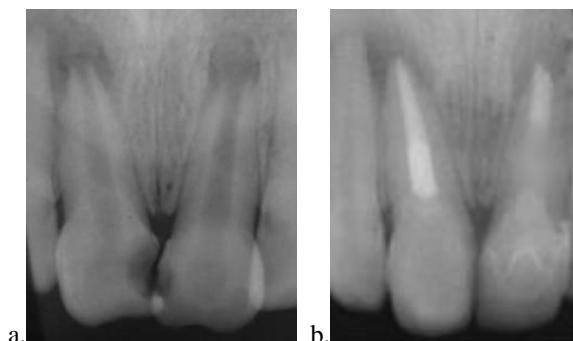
a) Radiographic of tooth 11 and 21 before treatment, showed open apex and apical radiolucency, b) Radiographic of tooth 11 and 21 after treatment. Apexification using MTA (BioMTA) had been done on both central maxillary incisors. Healing process happened on apical part of tooth 11 and 21.
